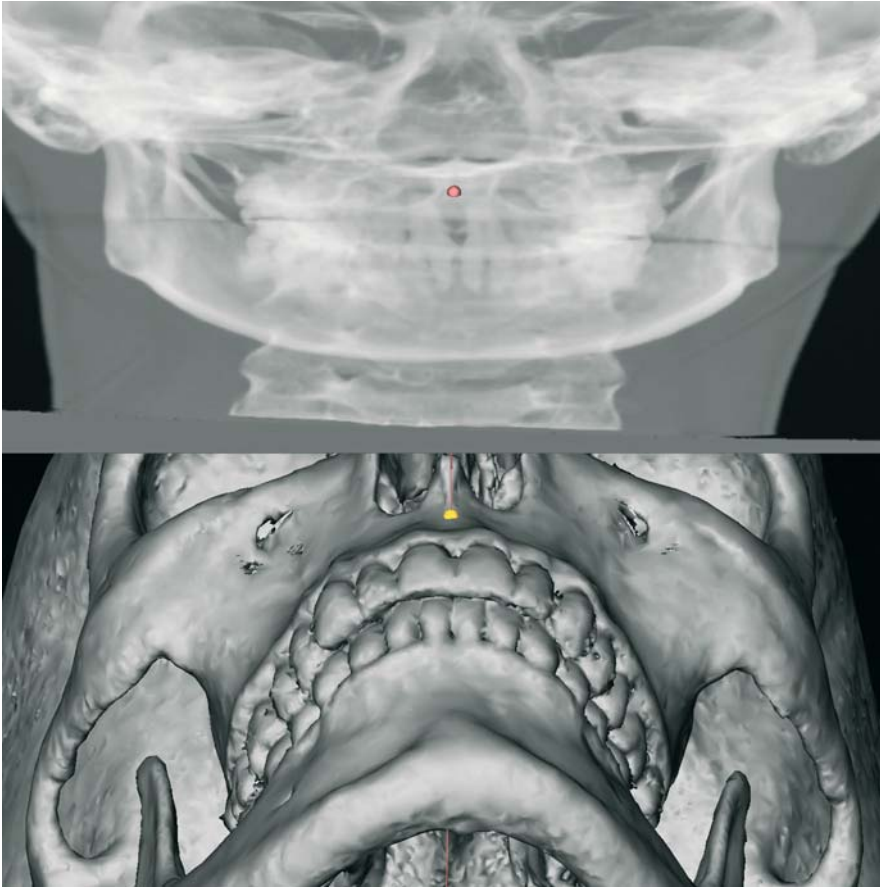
A-Point. Virtual frontal cephalogram linked to the 3-D hard tissue surface representation (3-D CT, patient K.C.)
